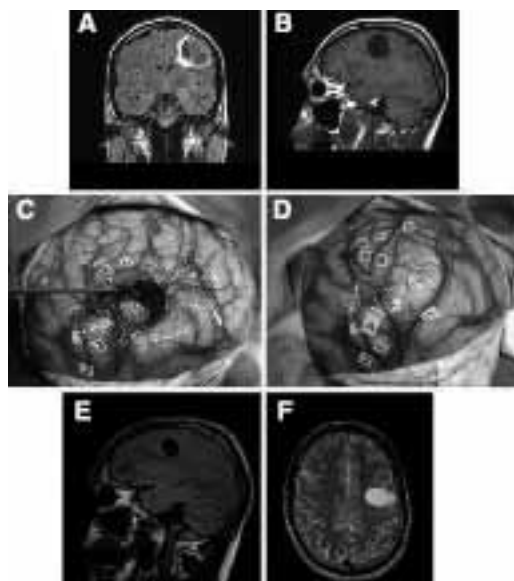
Preoperative coronal FLAIR (A) and sagittal T1-weighted (B) MR images showing a left precentral glioma involving the middle frontal gyrus. Intraoperative photographs (C and D) of cortical mapping: tags A, B, and C are tumor boundaries, as shown by intraoperative ultrasonography. Numbers 1, 2, and 3 indicate the primary motor area of the hand; 4, speech arrest with facial movements; and 5 and 6, speech arrest in the ventral premotor cortex. Subcortical mapping (D) showing the resection cavity with no margin between function and tumor, thanks to a subpial dissection along the precentral sulcus (spatula). The subcortical functional boundaries were the pyramidal fibers tract of the hand at the bottom of the sulcus (Number 37) and fibers coming from ventral premotor cortex inducing anarthria (Number 36)—both constituting the so-called projection fibers vertical connectivity—as well as phonemic paraphasia elicited by stimulation over the arcuate fasciculus, that is, long-distance association pathways or deep connectivity, or horizontal connectivity (Number 34). Postoperative coronal T2-weighted MR image (E) demonstrating the surgical cavity, which is directly in contact with the precentral sulcus where the subpial dissection was performed, with no residual tumor at this level and no margin. Sagittal FLAIR MR image (F) showing the inferior limit of the surgical cavity directly in contact with the arcuate fasciculus, which lies just above the insula.
